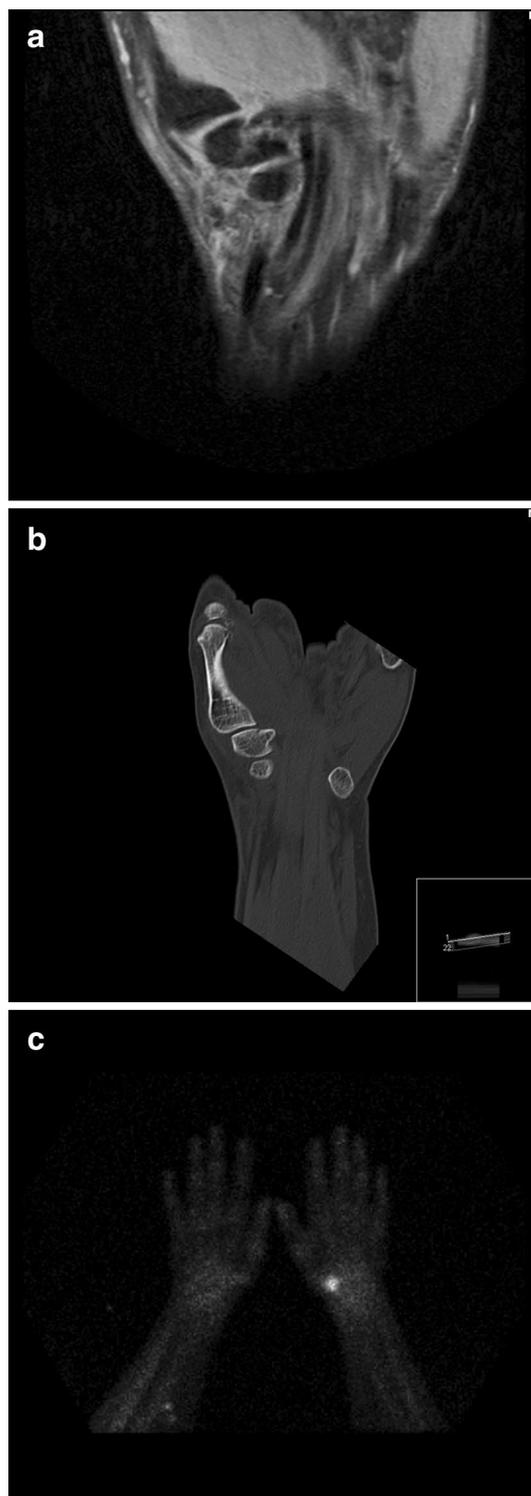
a T2 image of a MRI showing a trapezium fracture. b Image of a CT showing cortex interruption of the trapezium. c BS with activity in the scaphoid area. The nuclear physician reviewed this image as a scaphoid fracture
